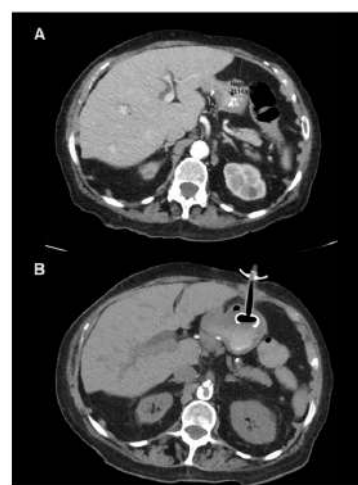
Abdominal Computed tomography scan image.
